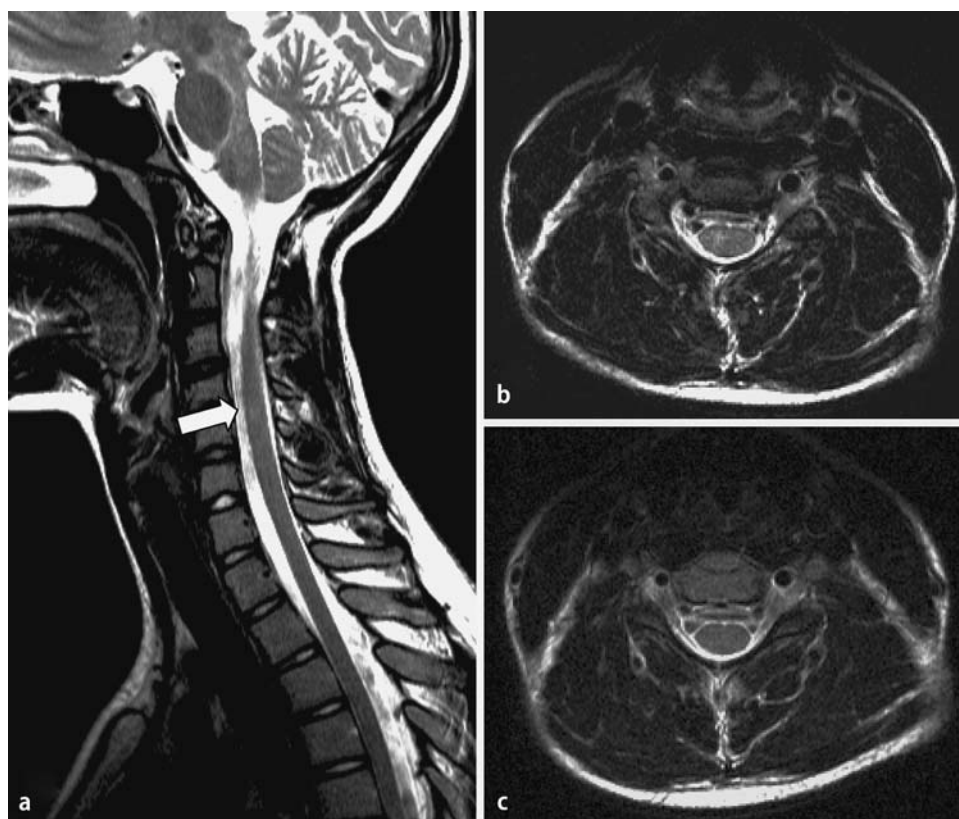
Baseline MRI demonstrated high signal intensity alterations in the cervical spinal cord (a, b). These abnormalities had already resolved at the time of follow-up after 3 weeks (c)
